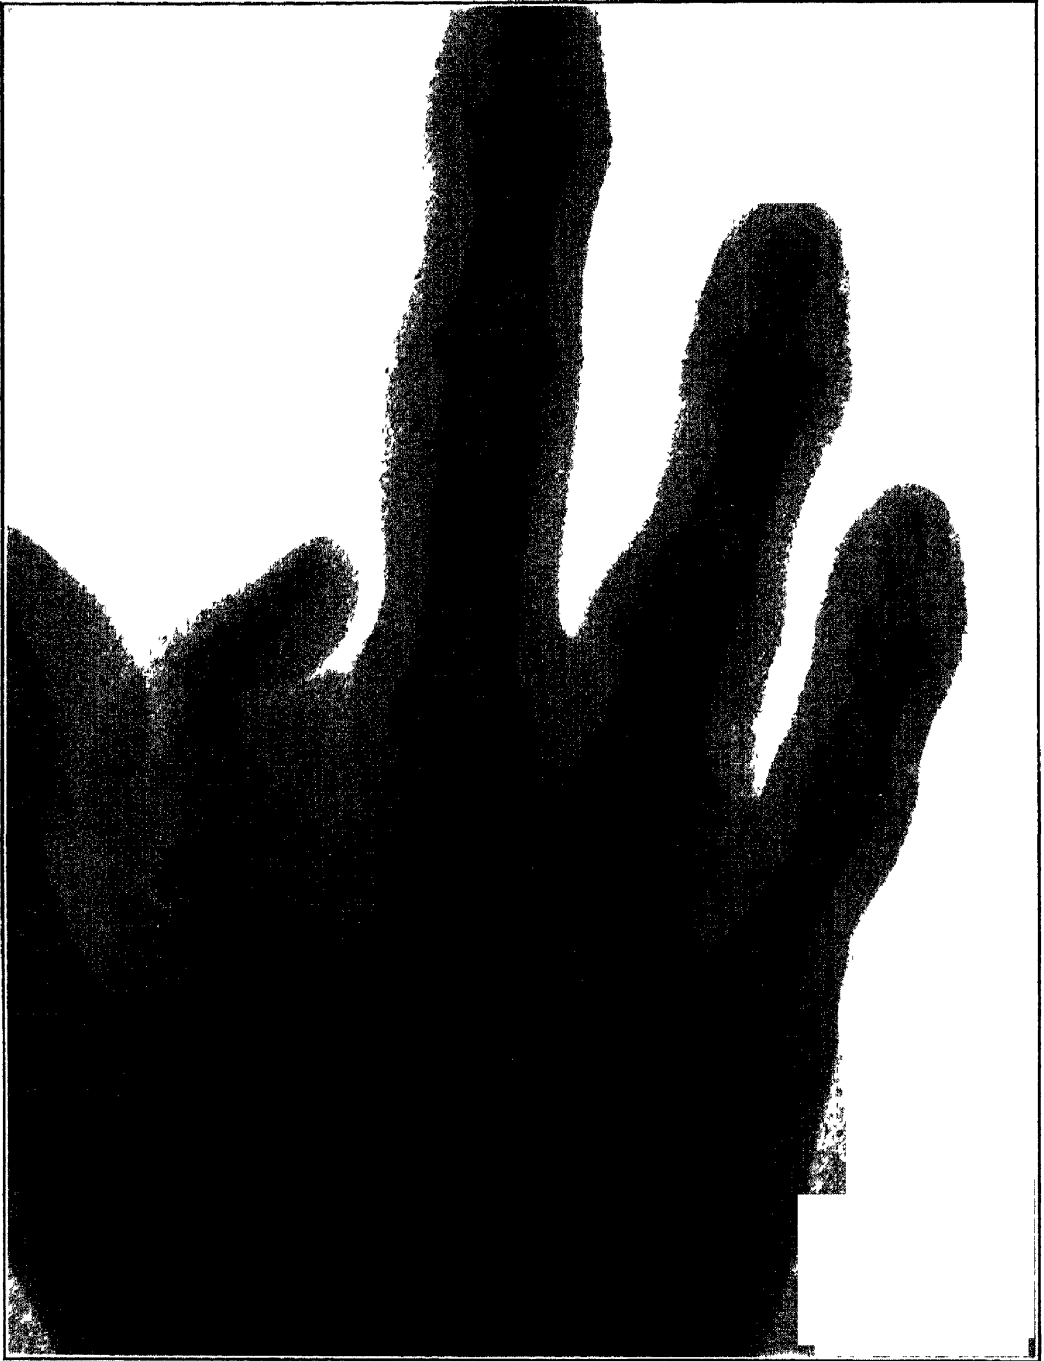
RADIOGRAPH OF A HAND IN WHICH THERE WAS EXTENSIVE LOSS OF BONE FOLLOWING SUPPURATIVE ARTHRITIS.
